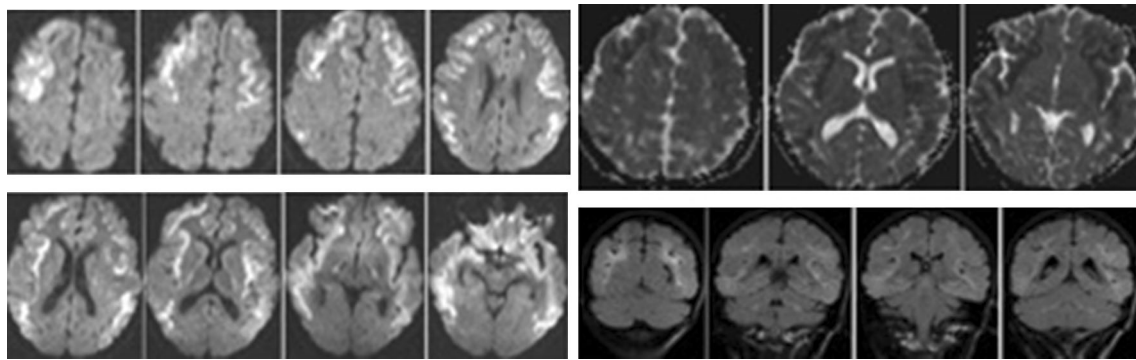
Bilateral cortical, subcortical hemispheric diffusion restriction corresponding ADC hypointensity. On flair MRI, hyperintensity is seen in the same localization
